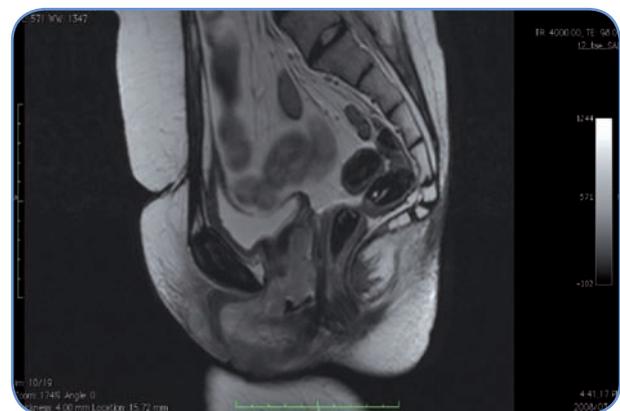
T2-MRI showing pelvic and perineal recurrence of a cervical cancer
